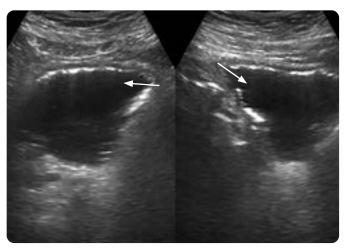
Urinary tract ultrasound, mode B. a) Sagittal plane. b) Transverse plane: Bladder with echogenic images on wall, without posterior acoustic shadow (arrows).
